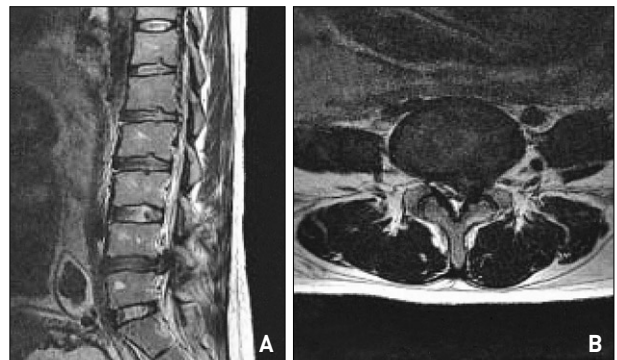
A : Sagittal and axial T2 weighted magnetic resonance images show huge disc herniation at L4-L5 level (left side).
